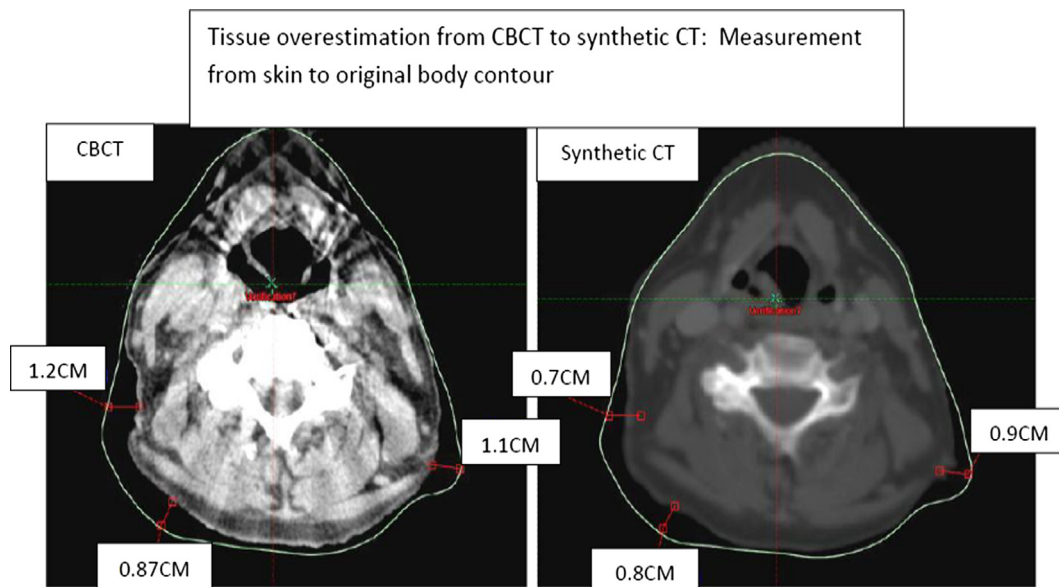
Tissue overestimation on synthetic CT.
